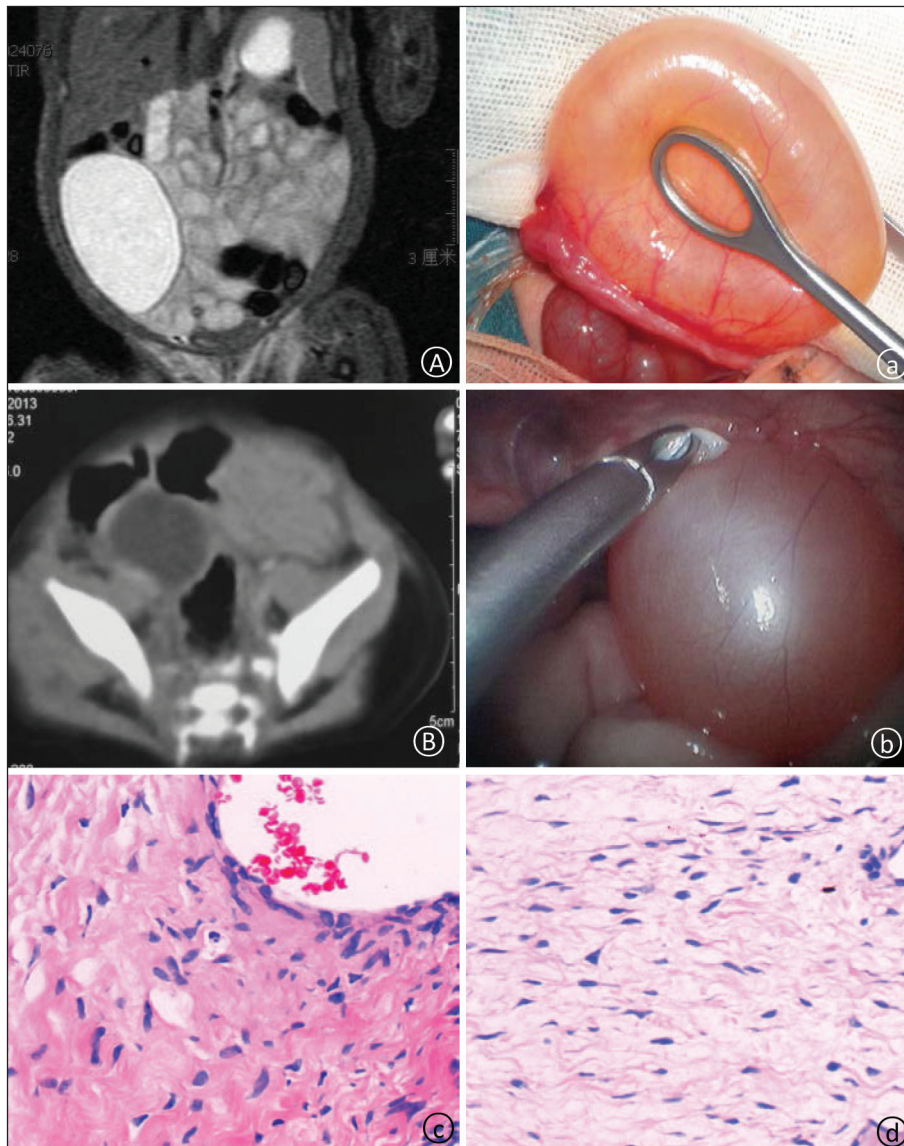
Preoperative MRI/CT examination indicated quasi-circular cystic low-density lump image, and it could not be distinguished from intestinal duplication and mesenteric cyst (A and B) that is proved to be an ovarian cyst during the surgery. At an early stage, laparotomy and fenestration were conducted for the cases; at the late period, the surgery was completed under trans-umbilical double-port laparoscope for the cases (a and b). The postoperative pathological result indicated simple ovarian cyst (c and d)
